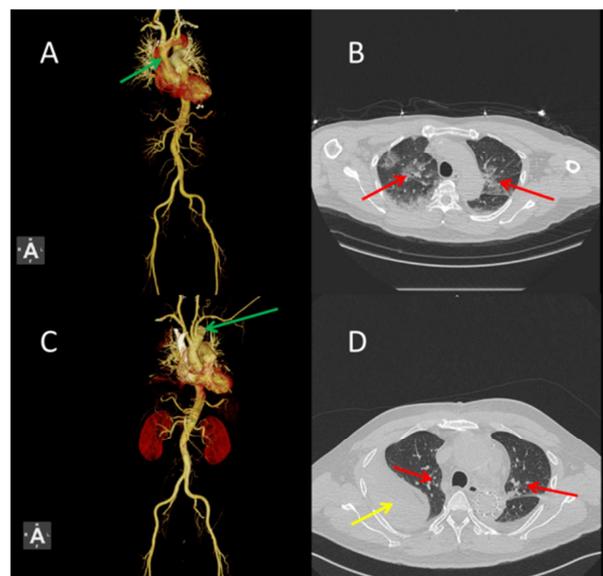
A: CTA of aortic dissection shows aortic dissection involving the root of the thoracic aorta, thoracic aorta, abdominal aorta, proximal mesenteric artery, and origin of the left common iliac artery (green arrow); B: Chest CT demonstrates diffuse patchy opacities in both lungs with a "butterfly-wing" pattern of changes (red arrow); C: CTA after aortic dissection shows patency of the artificial graft and stent in the aorta (green arrow); D: Postoperative chest CT shows that the diffuse patchy opacities in both lungs are improved compared with before (red arrow), and there is encapsulated pleural effusion in the right chest cavity (yellow arrow).
